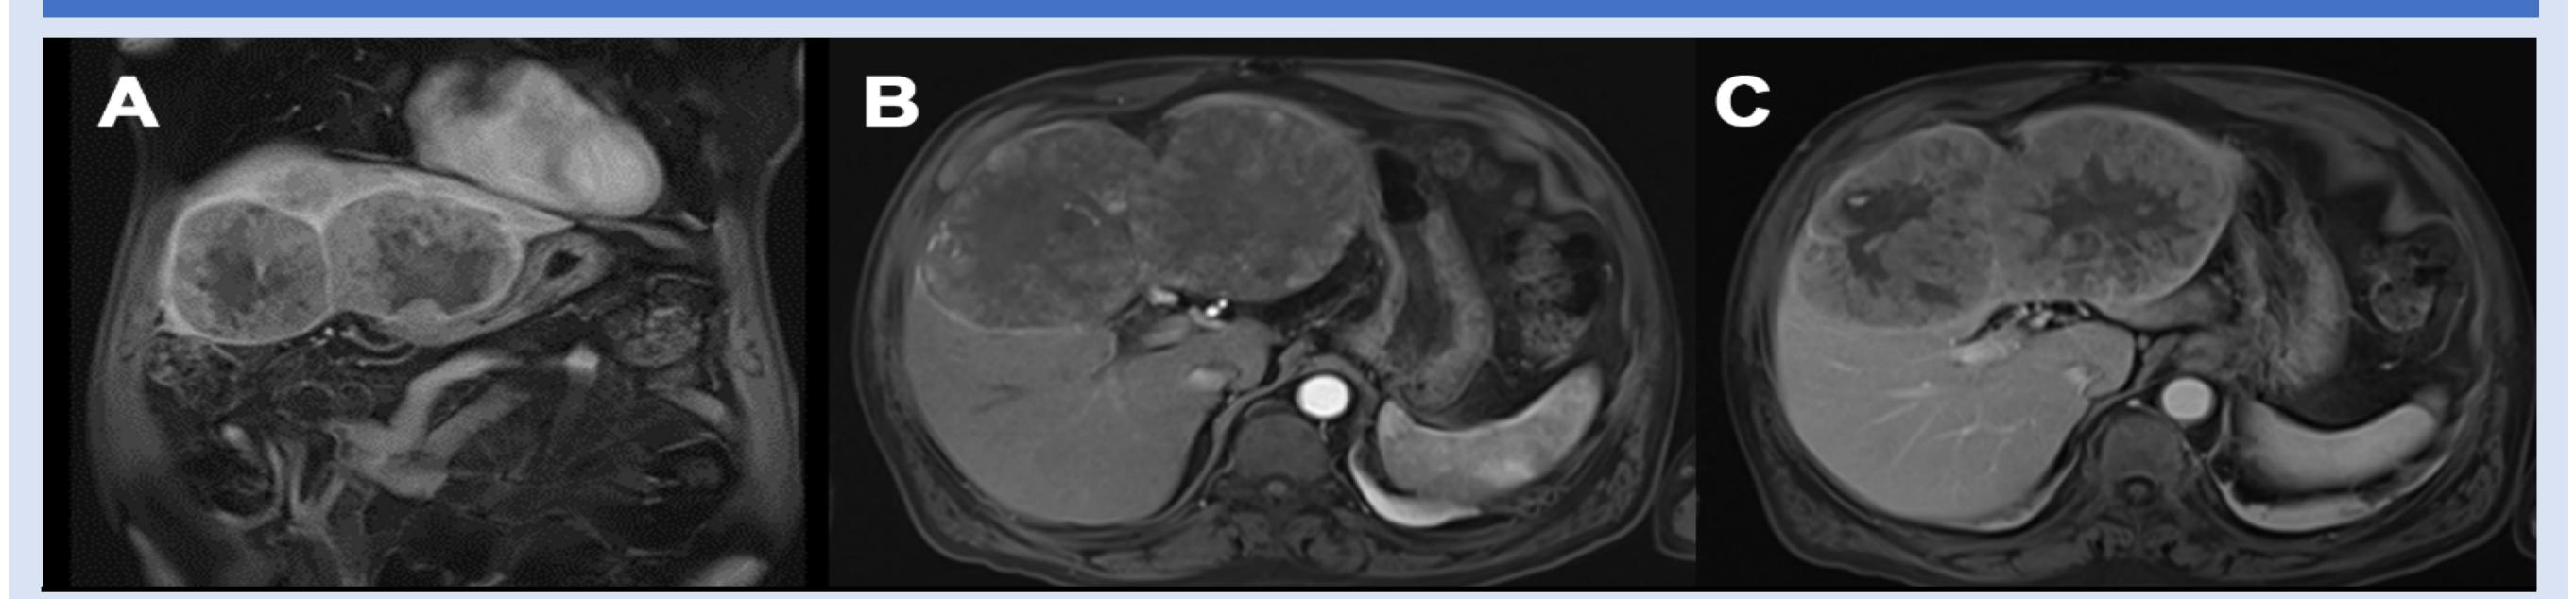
(A) Coronal and (B) axial arterial phase MRI through the abdomen demonstrating heterogeneously enhancing bi-lobed mass with non-enhancing central scar. (C) Axial portal venous phase MRI demonstrating portal venous washout with non-enhancing central scars in a bilobed mass.
